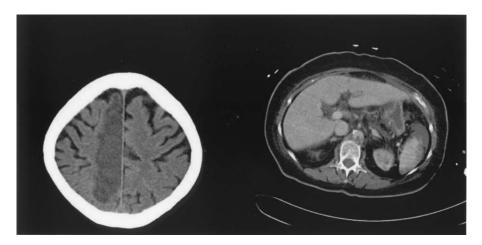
CT scans 11 hours postoperatively demonstrating a large frontal ischemic stroke and multiple spleen infarcts. An 83-year-old woman did not wake up after bypass surgery using the HEARTSTRING device and a blower mister for facilitating the proximal anastomoses. Air emboli caused by the devices were suspected.
